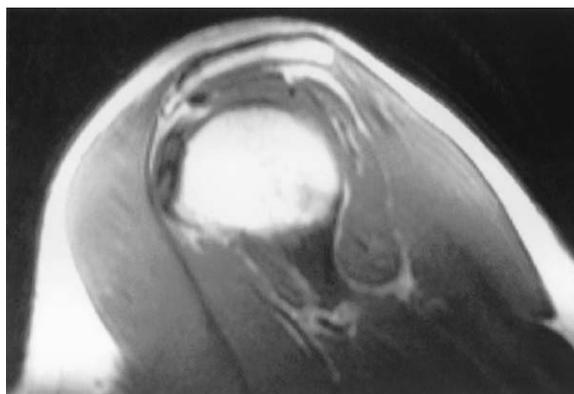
T1-weighted oblique sagittal MRI shows a type II acromion.
